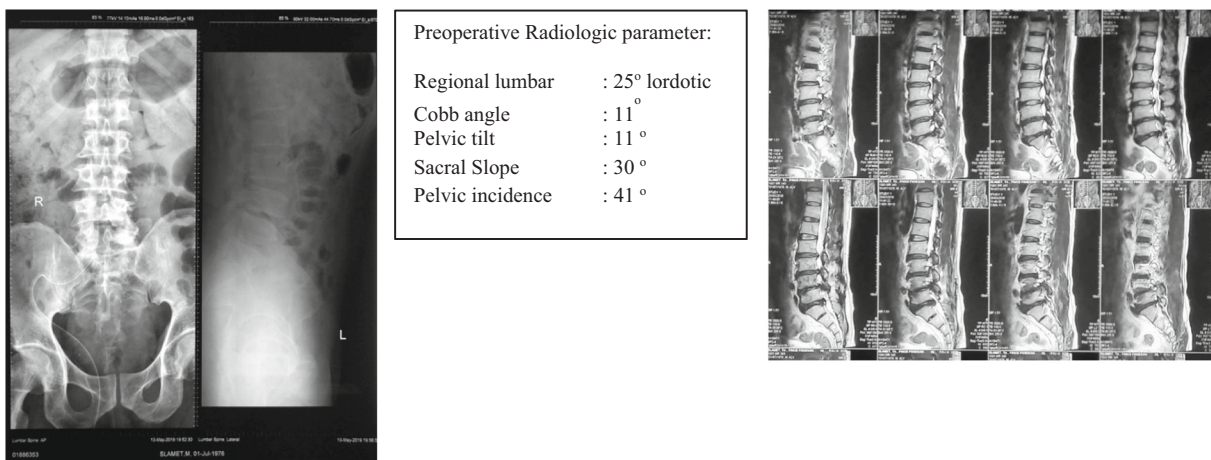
Case 4 initial radiograph presentation.
